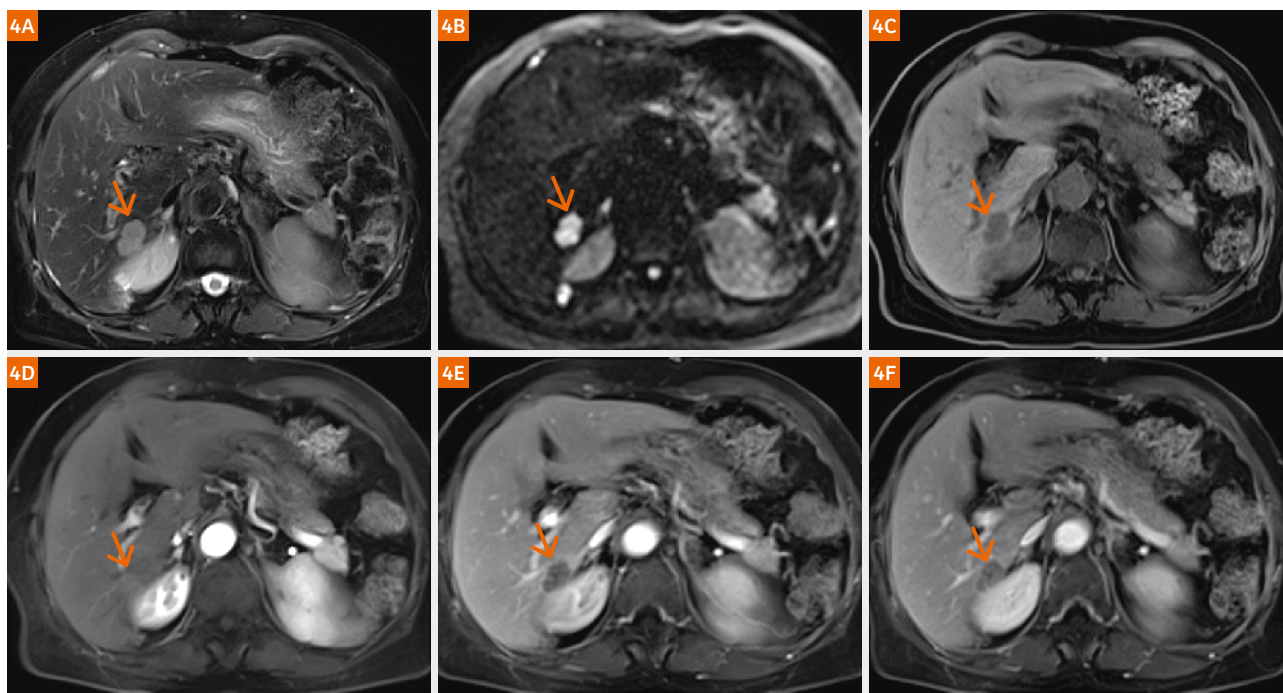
Liver metastasis (primary: colon cancer) in a 69-year-old man: (4A) T2-weighted BLADE; (4B) DWI, $b = 1000 \text{ s/mm}^2$; (4C) pre-contrast T1w; (4D-F) contrast-enhanced T1w. The lesion is isointense to hyperintense in T2-weighted images, is hyperintense in DWI, and has low intensity in T1-weighted images. Annular enhancement is visible in the venous and delayed phase of enhanced MR imaging relative to the surrounding liver parenchyma.
